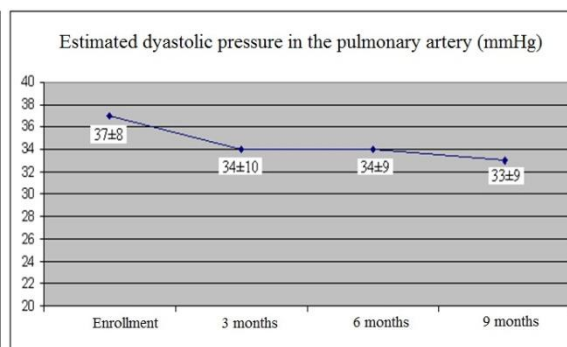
Evolution of DPPA, estimated by echocardiography, during the 9 months of monitoring.
